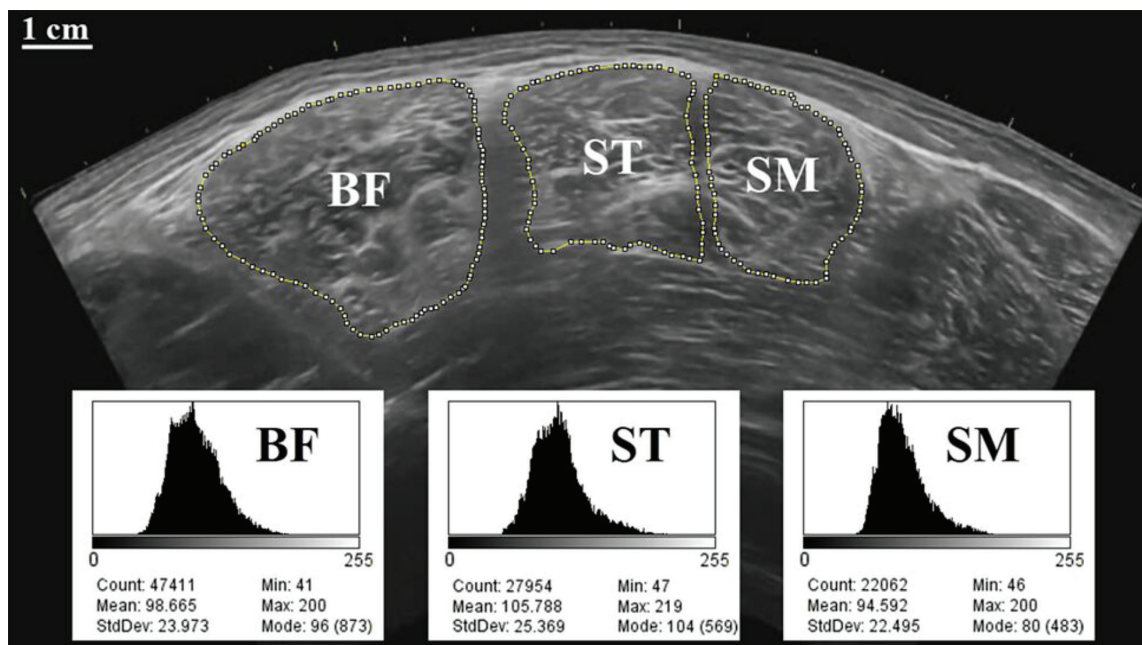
Transverse plane panoramic ultrasound image of the long head of the biceps femoris (BF), semitendinosus (ST), and semimembranosus (SM) muscles. Hamstring muscle cross-sectional area (CSA) and echo intensity (EI) values were determined by taking the sum of the CSAs and the mean of the EIs of the BF, ST, and SM muscles, respectively. Examples of the corresponding gray-scale histogram values from each muscle are provided.
